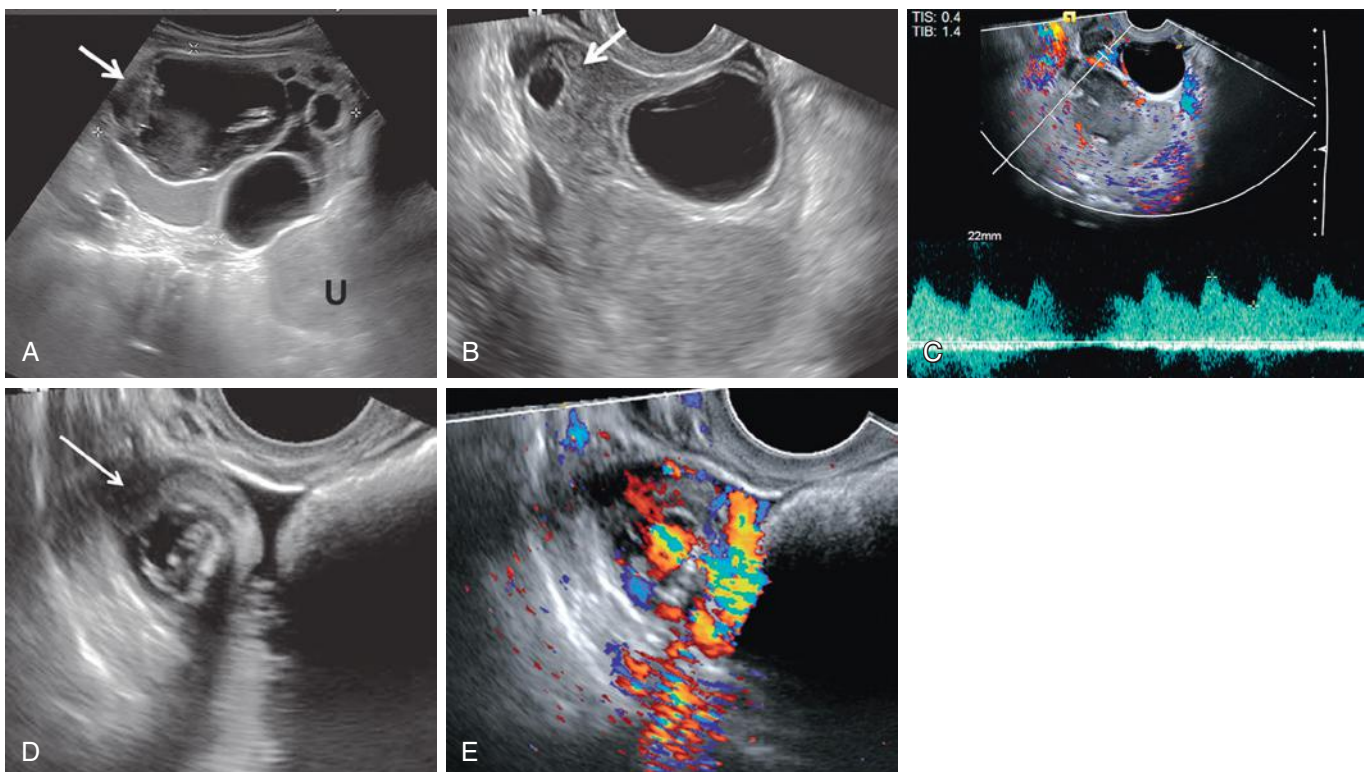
Ovarian torsion with mucinous cystadenoma and viable ovary. A, Transabdominal scan demonstrates large multiloculated complex cystic mass (arrow and calipers) located superior to the uterus (U). B, Transvaginal scan demonstrates edematous ovarian tissue around the mass with peripheral follicle (arrow) and a small amount of adjacent free fluid. C, Arterial and venous flow to the ovary are preserved, shown on color and spectral Doppler sonogram. D, Gray-scale image of twisted pedicle with “target” appearance (arrow). E, “Whirlpool” appearance of vascular pedicle on color Doppler sonogram.
